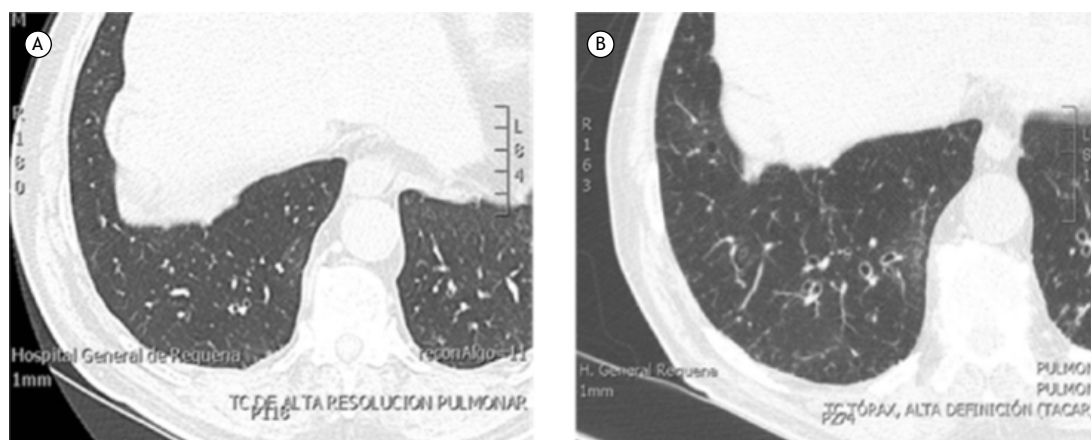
CT scans of a patient without bronchiectasis (A) and showing the development of bronchiectasis seven years later (B). With permission of the Journal of Clinical Infectious Disease.
